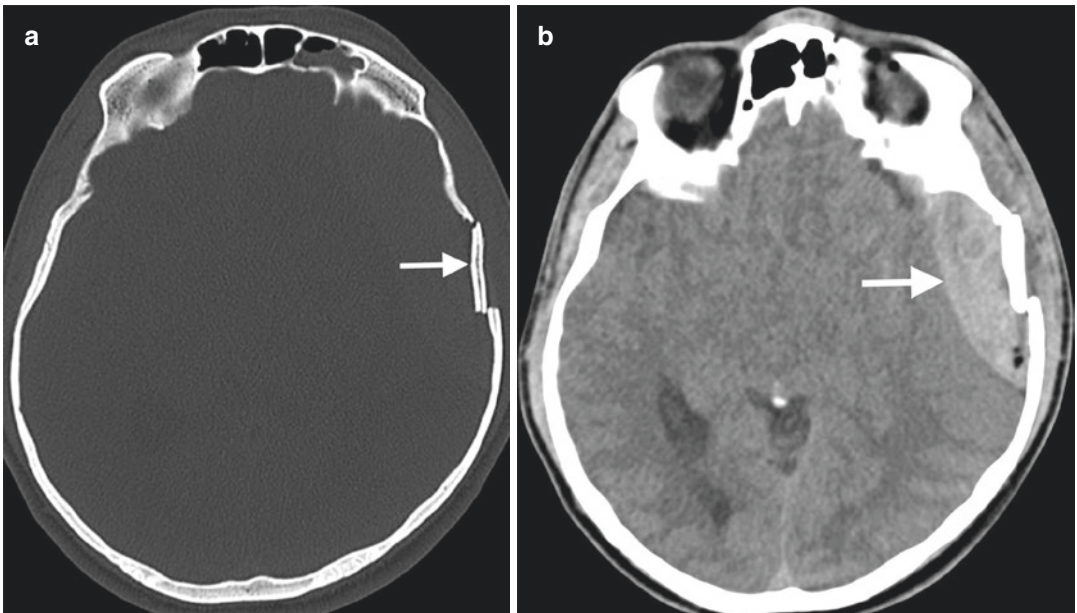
Depressed fracture in temporal bone. (a) Axial CT image on bone window shows a depressed temporal bone fracture characterized by displacement of fracture fragment (arrow) from the uninvolved temporal bone part. (b)
